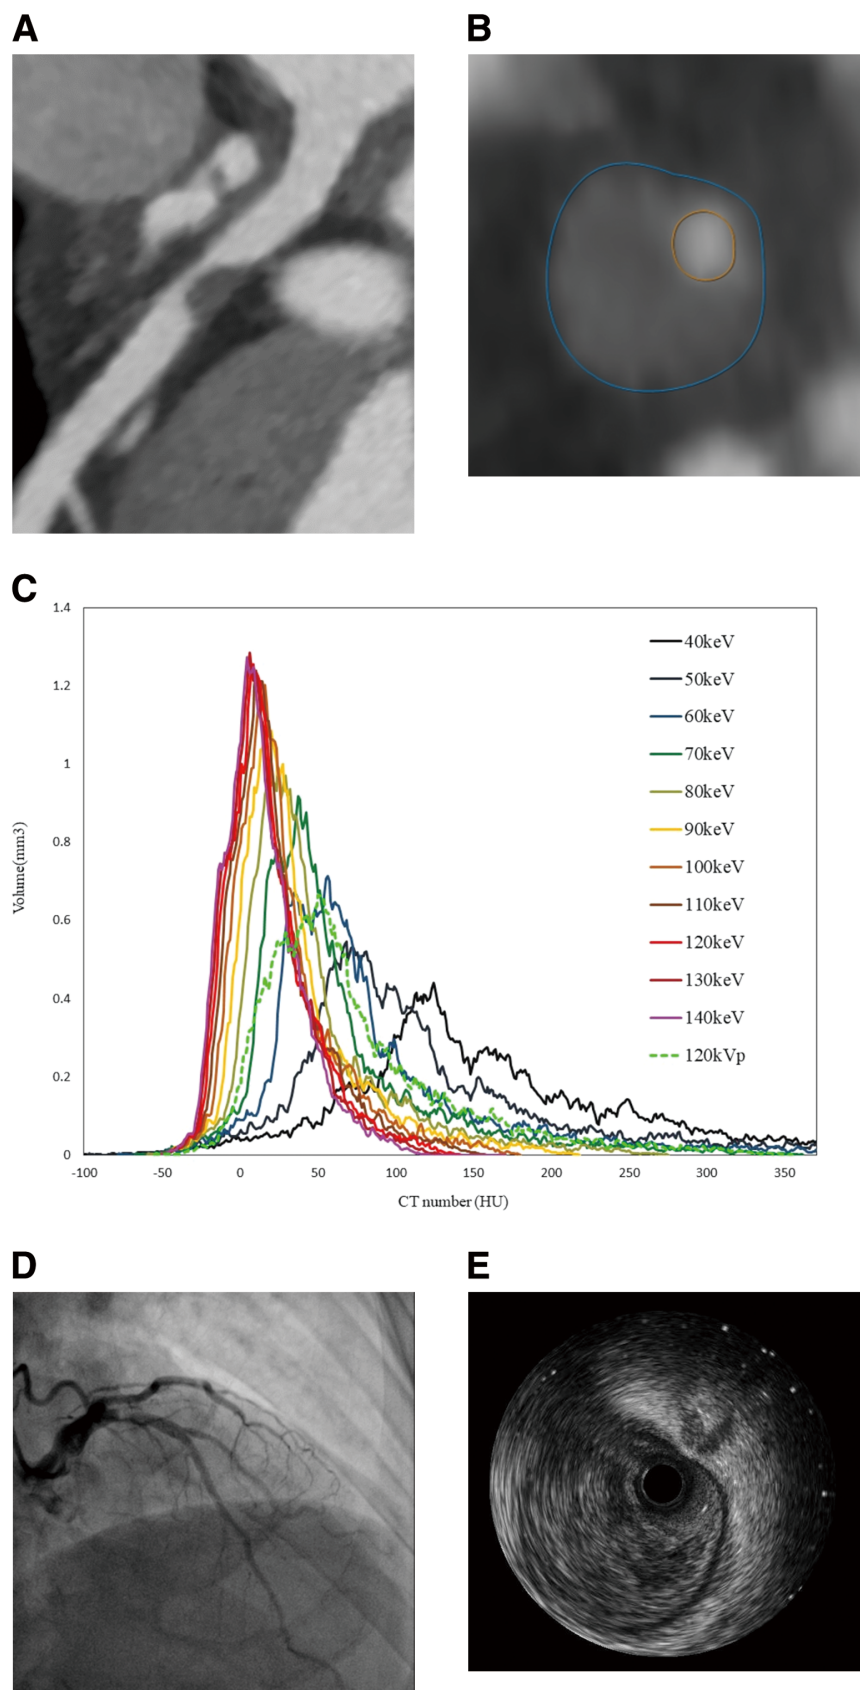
Representative case. Cardiac computed tomography (CT) curved multiplanar image (A) and short-axis image (B) showed stenosis in the left anterior descending artery #6. Plaque histograms (C) at 120kVp and virtual monochromatic image at different energies showed that the histogram shape changed with energy. Angiography (D) and intravascular ultrasound (E) showed a vulnerable plaque. In this case, the spectral imaging analysis indicated that the plaques were unstable. As a result, distal protection was used to prevent embolization; after percutaneous coronary intervention, there was a transient reduction in blood flow that quickly recovered.
